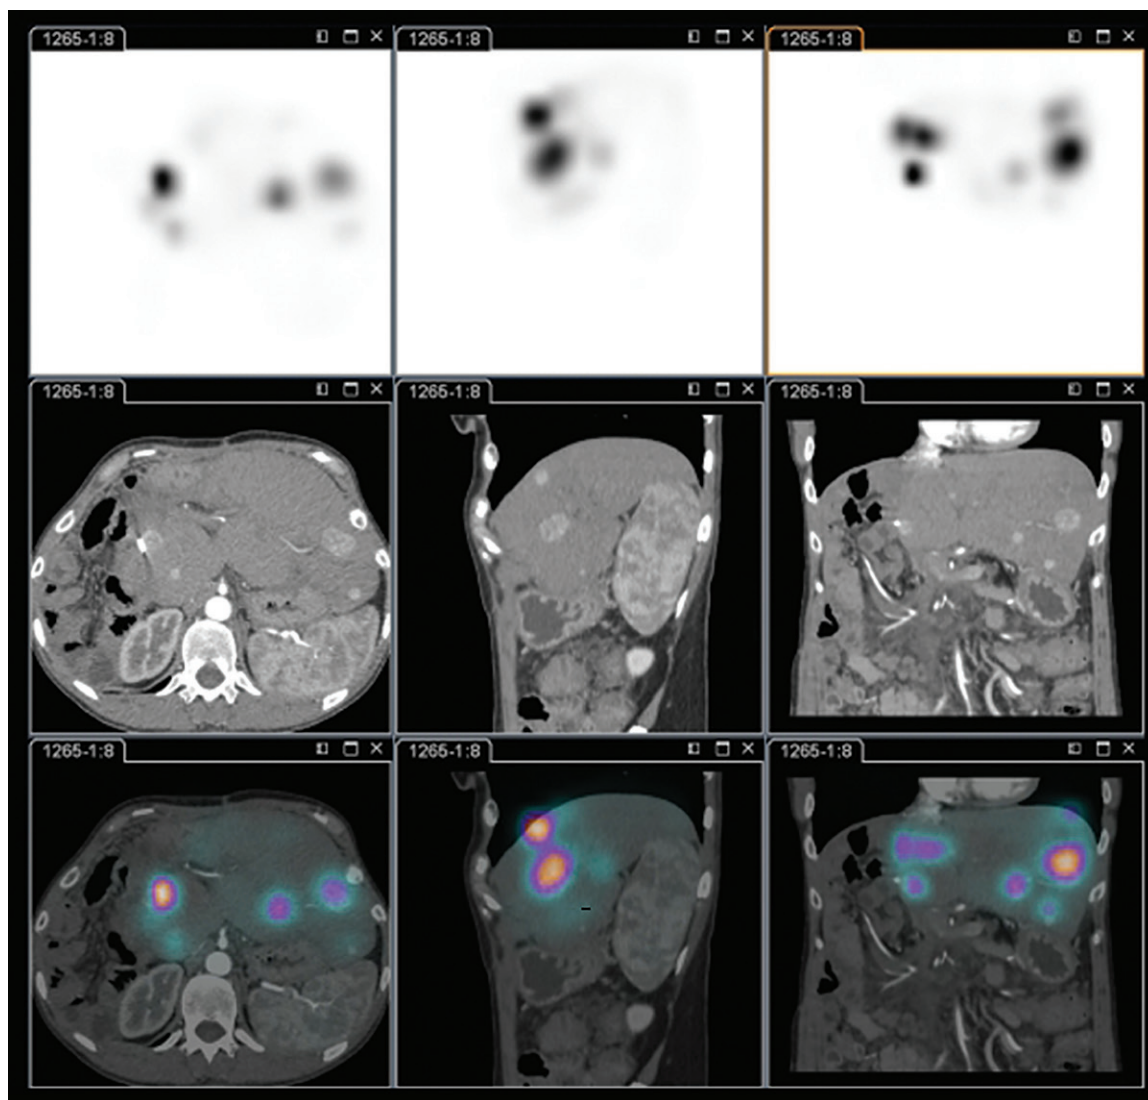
^{99m}Tc -MAA uptake in liver tumors in a 42-year-old woman. Axial (left), sagittal (middle), and coronal (right) SPECT (top row), CT (middle row), and fused SPECT/CT (bottom row) images show several liver tumors. The SPECT/CT images show high intratumoral uptake of ^{99m}Tc -MAA in the liver lesions (round colored regions) and minimal uptake in the normal (noncolored) liver parenchyma.
